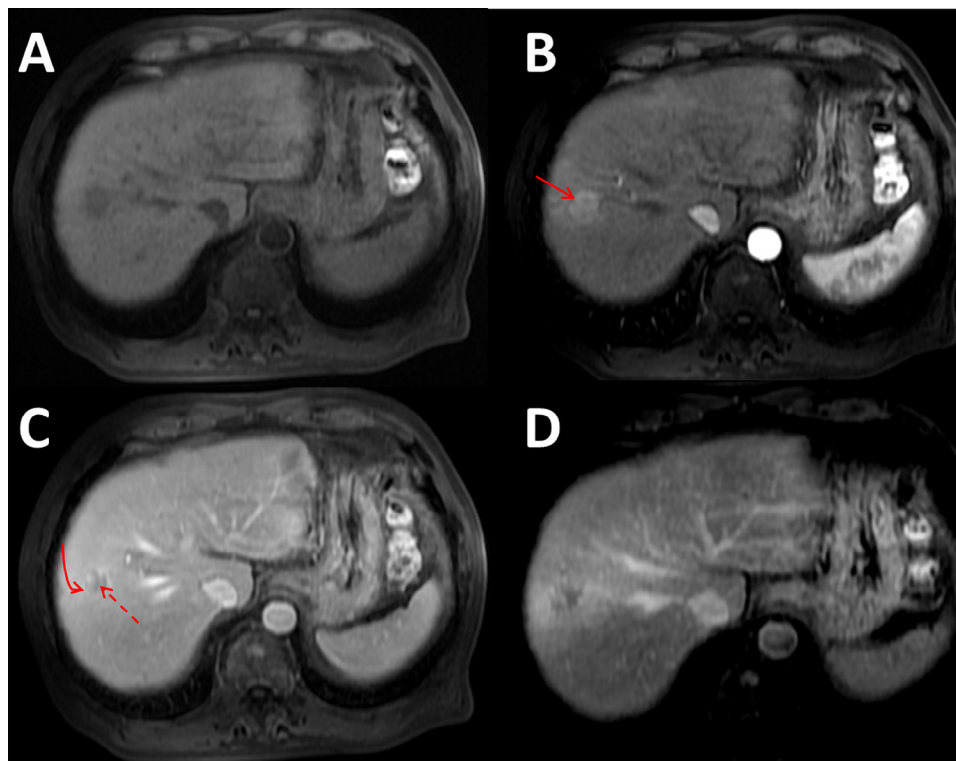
Axial magnetic resonance images of the liver in the precontrast (A), arterial (B), portal venous (C), and delayed phases (D) demonstrate a hepatic segment VIII T1 hypointense lesion demonstrating hyperenhancement on arterial phase imaging (solid arrow), washout kinetics on portal venous-phase imaging (dashed arrow), and an enhancing capsule (curved arrow) with imaging features in keeping with a hepatocellular carcinoma.
